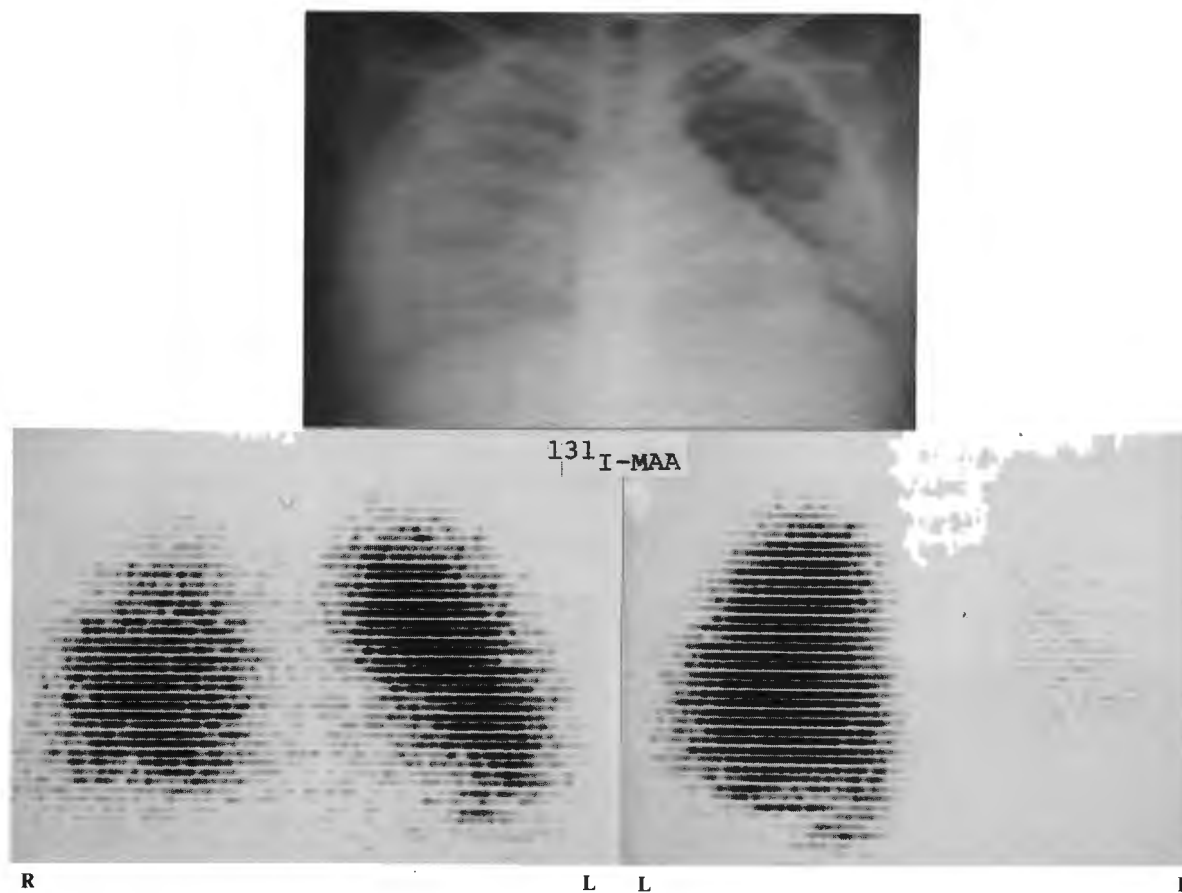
Interference of pleural fluid on dual-headed scanner study. Anterior scan (*lower left*) shows minimal diminution in right lung perfusion. Posterior scan (*lower right*) demonstrates much more severe apparent diminution in right lung activity due to interposed pleural fluid shown on chest x-ray (see text for explanation).
